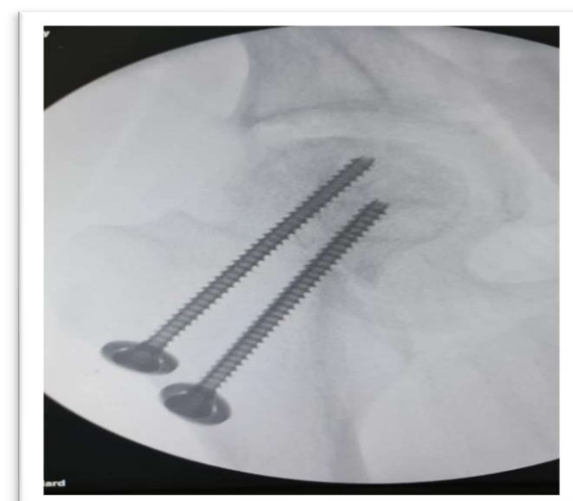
Post operative radiograph after the procedure
